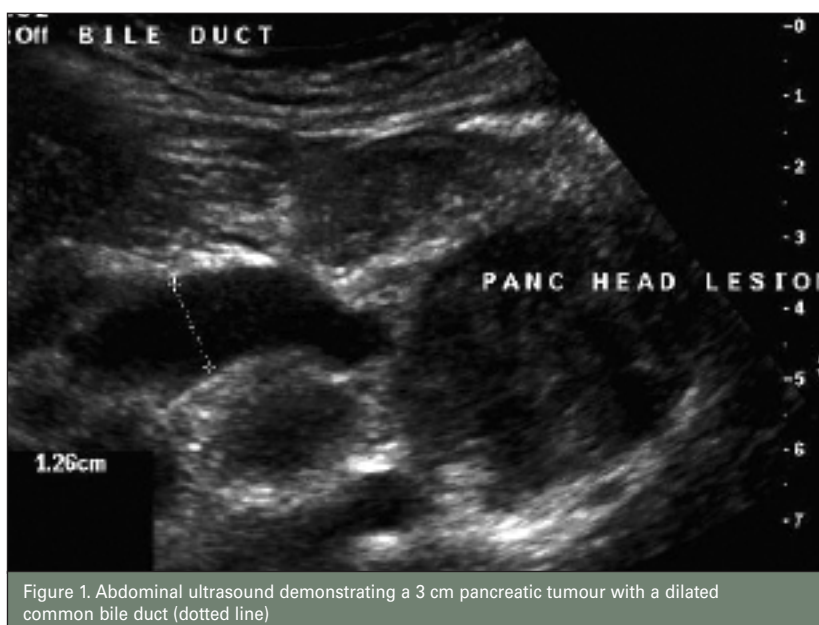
Abdominal ultrasound demonstrating a 3 cm pancreatic tumour with a dilated common bile duct (dotted line)
